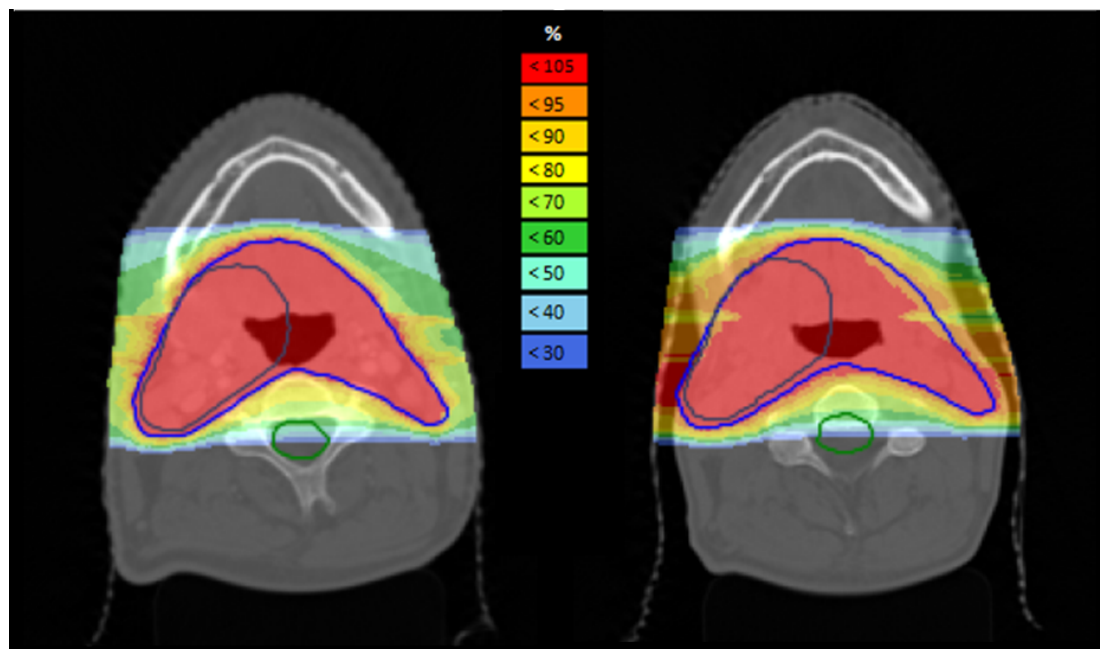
Representative slice of a Carbon ion dose distribution for a Head and Neck cancer patient. Left hand side represents the nominal treatment plan while right hand side shows the nominal treatment plan recalculated on the basis of a CT acquired during the course of fractionated RT exhibiting weight loss of the patient.
